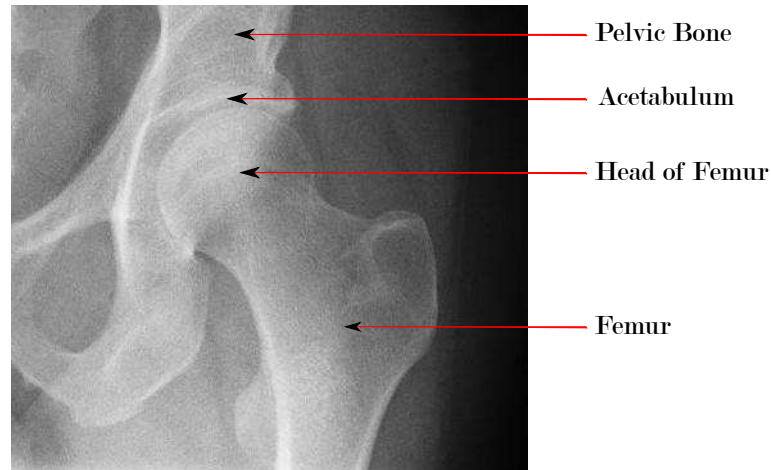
An x-ray of a healthy human hip joint [3]
